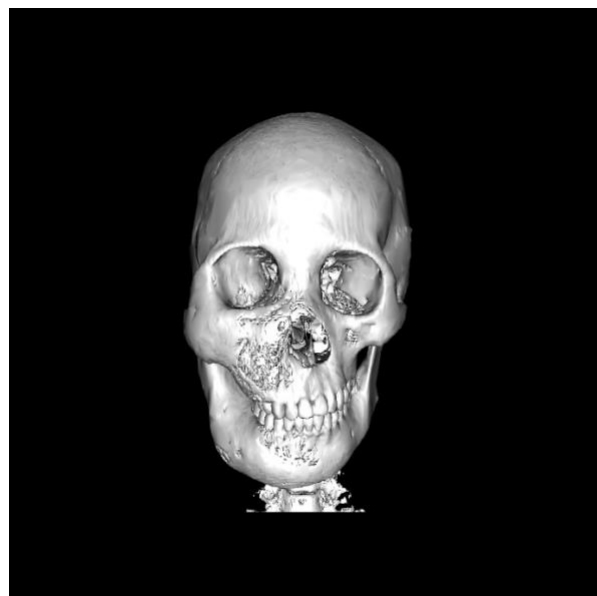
3D reconstruction from CT Scan
